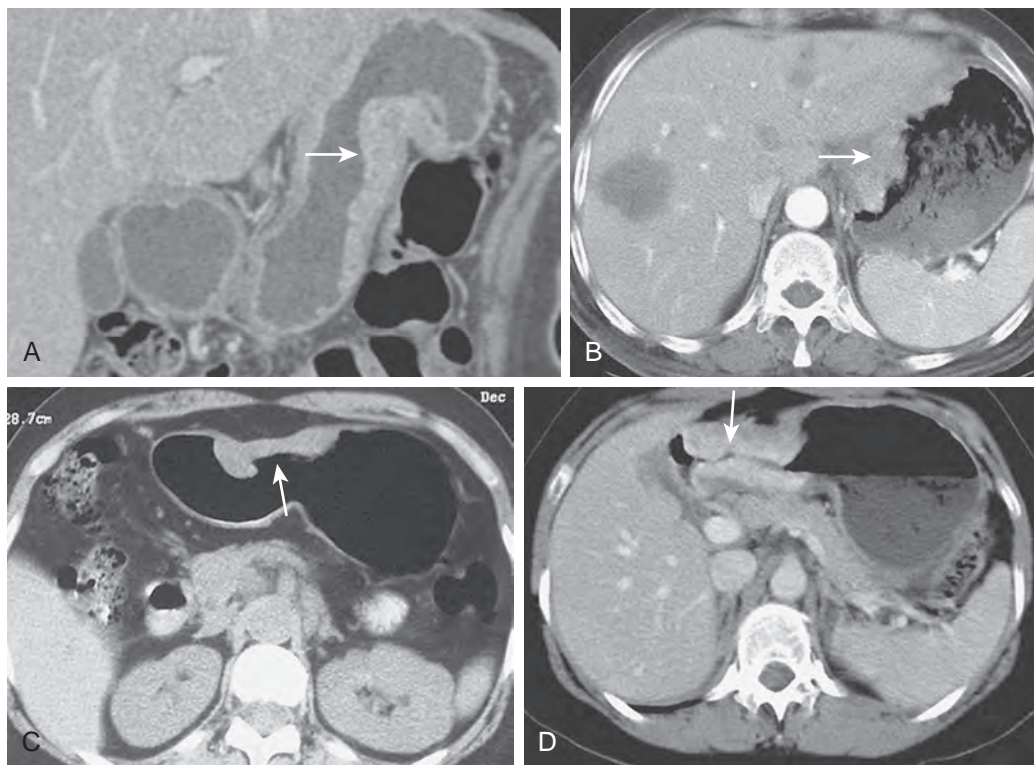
MDCT of gastric carcinoma correlated with Borrmann classification. Images from four different patients show the various CT appearances of gastric carcinoma (arrows). A. Type I polypoid neoplasm. B. Type II fungating neoplasm. Also note the presence of multiple hepatic metastases in this patient. C. Type III ulcerated neoplasm. D. Type IV infiltrating neoplasm.
